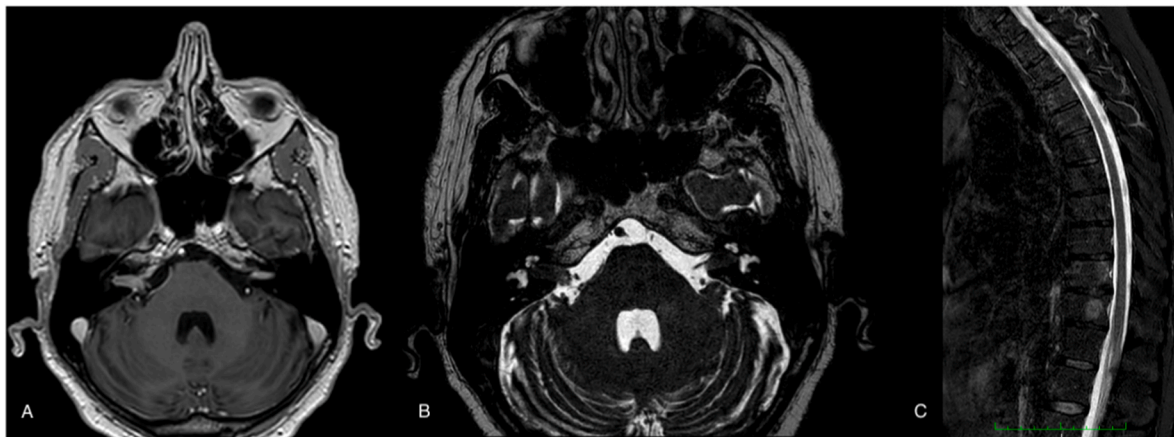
A-B IACs lesion at MRI. C-D1 level spine lesion at MRI.
